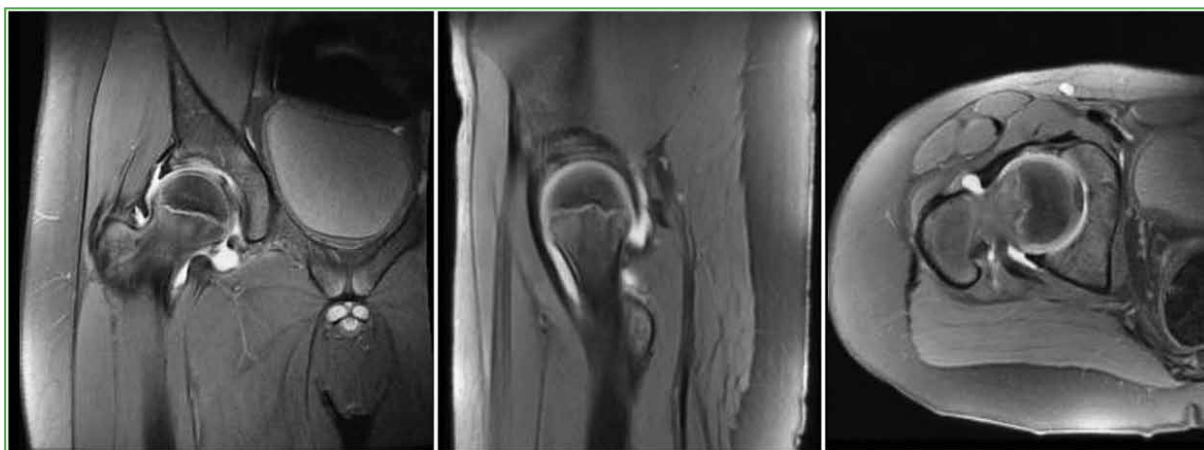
Magnetic resonance imaging of the hip, coronal, sagittal and axial planes, respectively, in PD FSE sequences. Hip joint effusion is observed, with preserved femoral and acetabular morphology, without signs of bone compromise.
